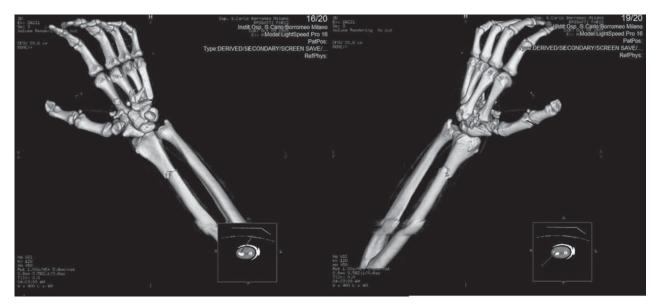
Pre-operative 3D-CT of the injured hand
